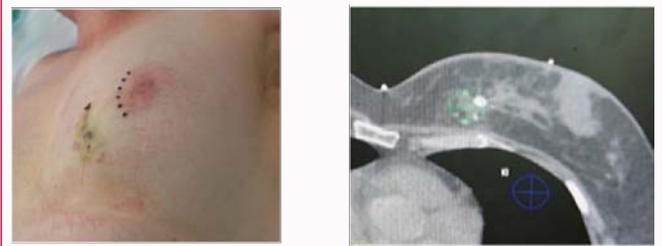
A) Patient with left medial quadrant tumor excised via periareolar incision. B) CT scan shows skin marker at areolar incision and marker (outlined in green) distant from incision site. Accurate marking of the tumor bed is critical for boost targeting and can be challenging with oncoplastic reconstruction of the partial mastectomy defect.
